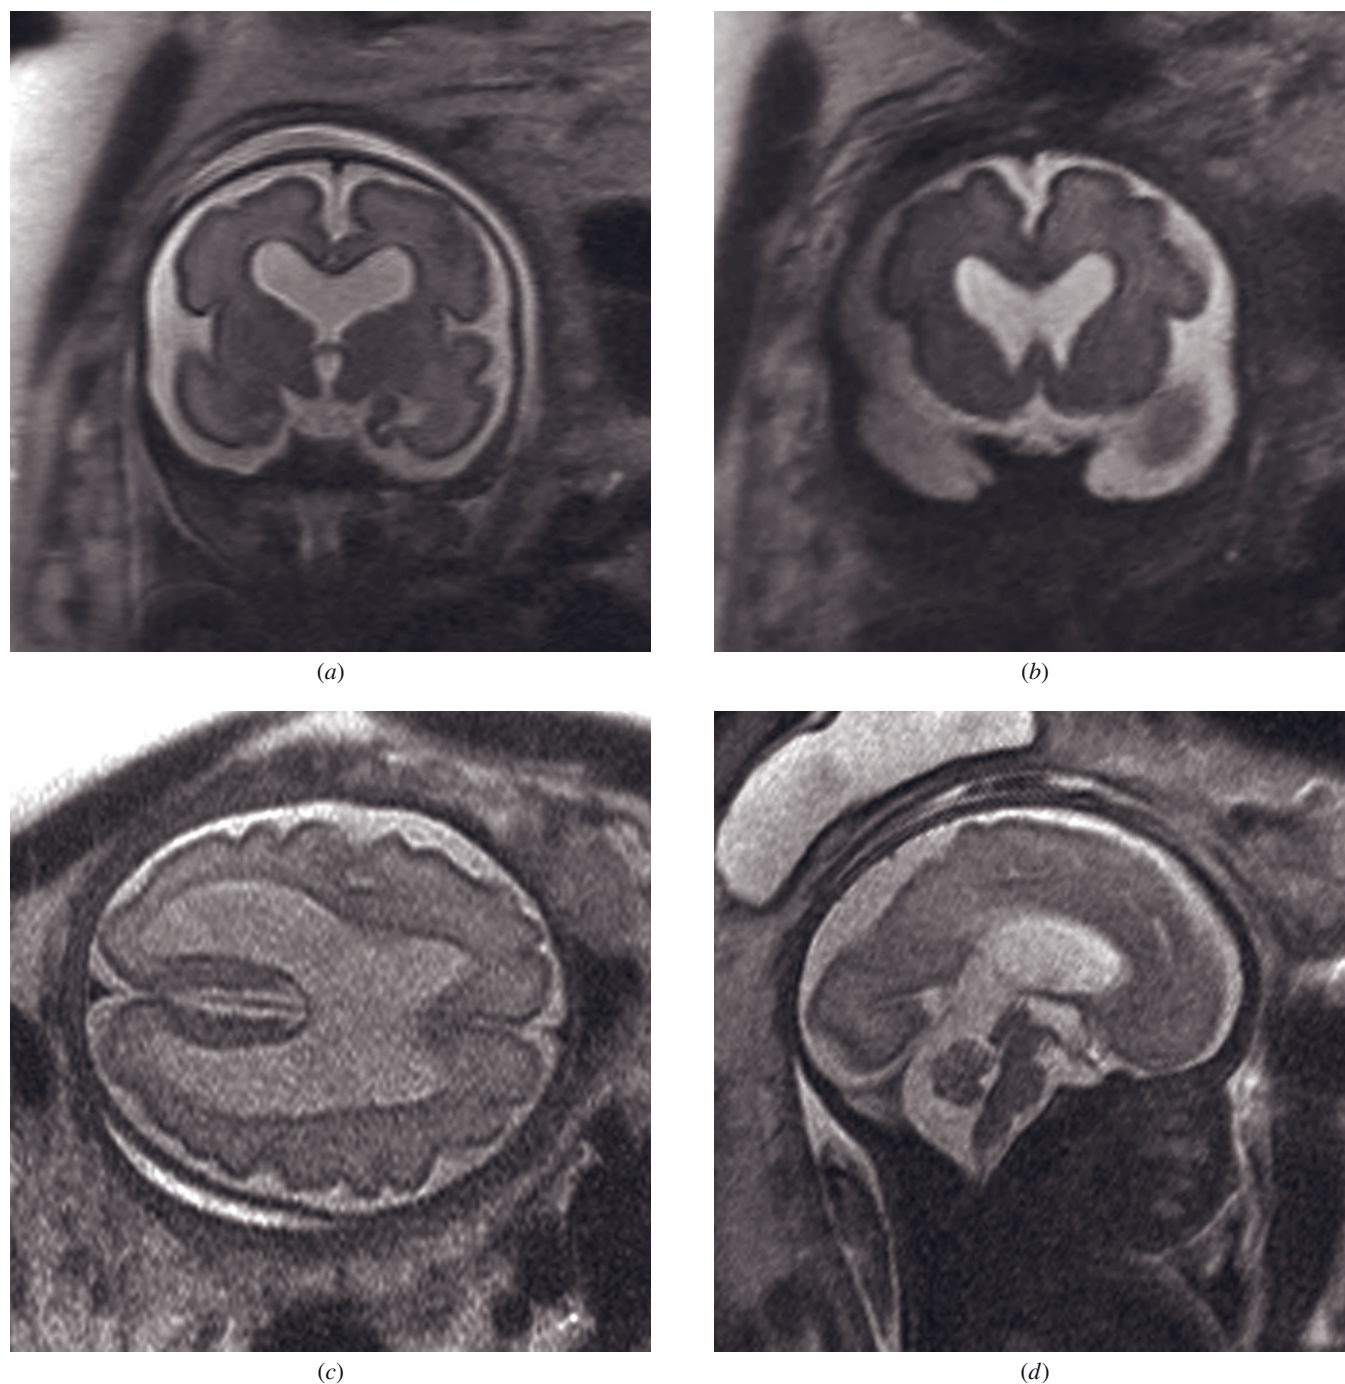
Septo-optic dysplasia. T2-weighted SS-ETSE images in a fetus at 28 weeks of gestational age. The coronal (*a*, *b*) and axial (*c*) images show complete absence of the cavum septum pellucidum, with flattening of the roof of the lateral ventricles and inferior pointing of the frontal horns. On the sagittal image (*d*), the low position of fornices is observed. Optic nerve hypoplasia is identified on coronal (*a*) and sagittal (*d*) images. Note the enlarged lateral ventricles.
